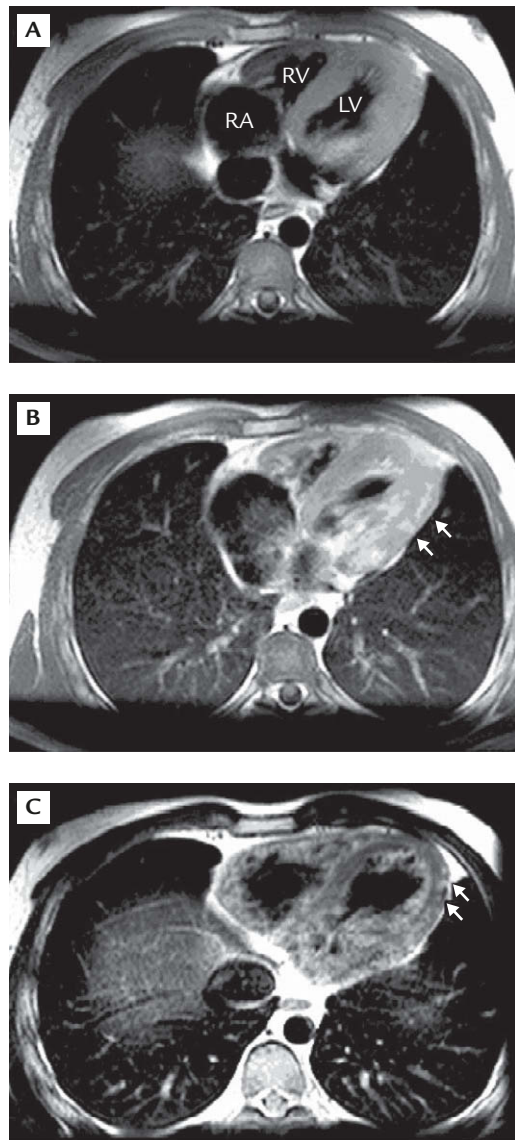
(A) T1-weighted sequence prior to contrast administration, and (B) post-contrast demonstrating patchy signal enhancement (arrows) at the lateral and inferolateral walls. (C) T2-weighted transverse image demonstrating patchy signal enhancement at the same regions, which suggested focal edema and inflammation.
